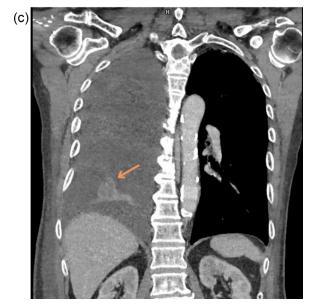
(A) Anteroposterior chest radiograph showed right pleural effusion and complete linear fracture (orange arrow) of right posterior 7th and 8th costae. Contrast-enhanced thoracic CT images axial and coronal view (B,C) showed a low density solitary nodule (orange arrow) inside passive atelectasis area in the right pulmonary segment 9-10 with pleural effusion.
